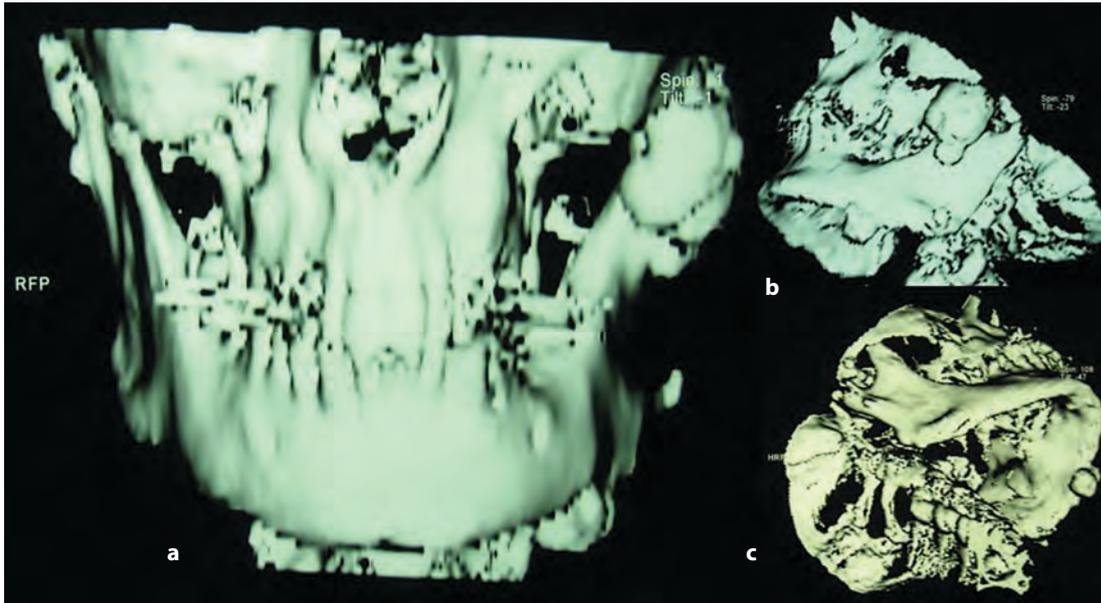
A, B and C: Computed tomography scans showing multiple osteomas of the mandible, maxilla, left ramus, maxillary antrum and pterygoid processes.
